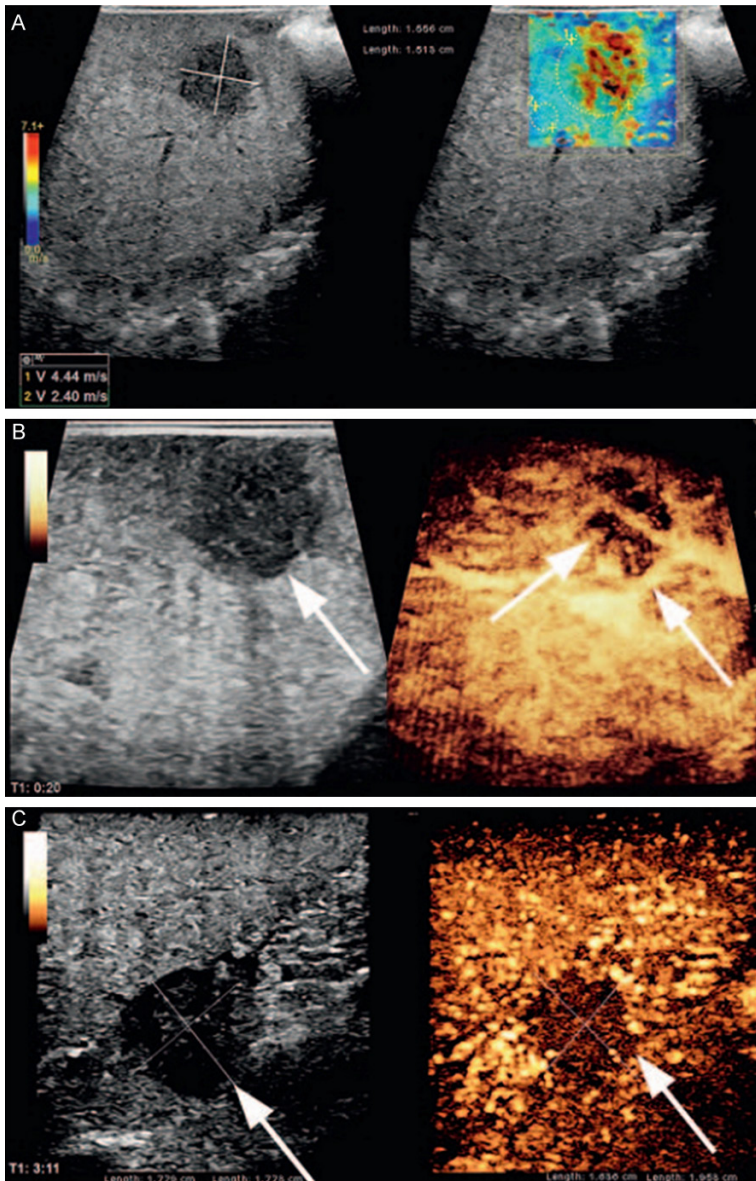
The CEUS and UE manifestations of primary liver cancer. The SWV value of the lesion was 2.4 m/s. A. General deformation, blue around the lesion, and green in a small part of the center. B and C. White arrows showed an excessive heterogeneity at the edge of the lesion of arterial phase via CEUS, suggesting a malignant tumor. SWV, shear wave velocity; UE, ultrasound elastography; CEUS, contrast-enhanced ultrasound.
